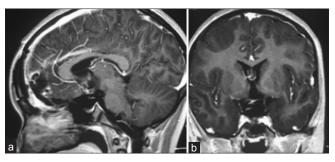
Patient 2: T1 contrast enhanced (a) Sagittal and (b) Coronal MR images showing the postoperative appearance after total tumour excision
